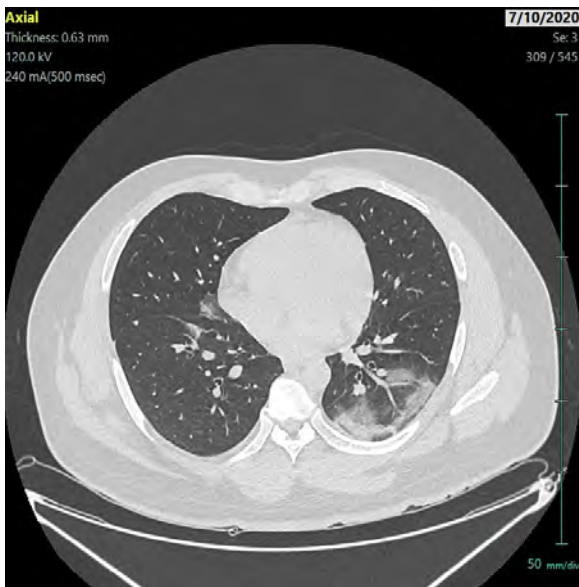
HRCT chest axial and coronal images showing bilateral predominantly peripheral ground glass opacification with consolidations in the lower lobes.
